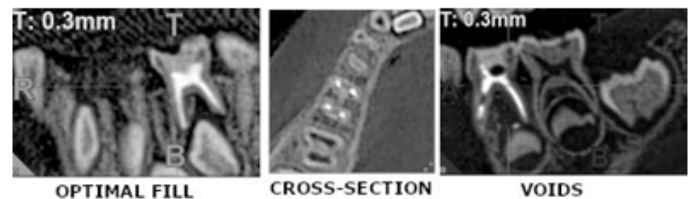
CBCT Scans Used For Assessment And Scoring : (a.) Optimal Fill (b.) Cross-Section (c.) Voids
